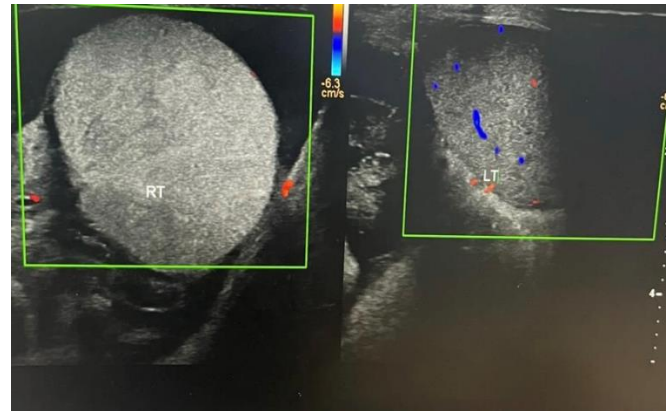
Colour Doppler ultrasonography of the scrotum demonstrating complete absence of intratesticular blood flow in the right testis (left panel), consistent with acute testicular torsion. Normal vascularity is preserved in the contralateral left testis (right panel). Absence of Doppler signal in the affected testis is a highly sensitive and specific indicator of testicular torsion in the paediatric population [8].
